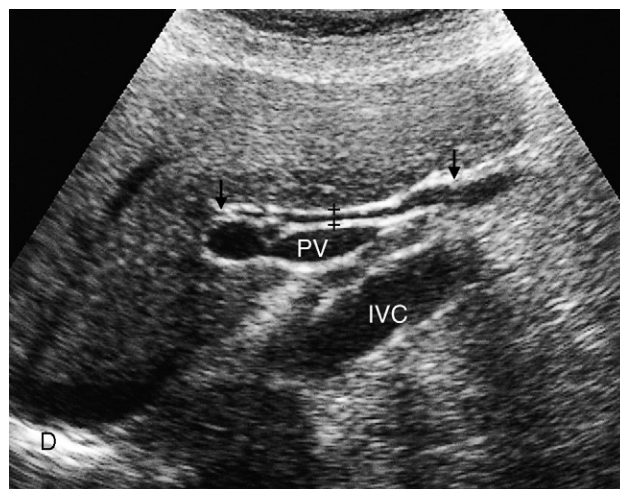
Normal common bile duct. Longitudinal ultrasound scan showing the common bile duct, situated between the arrows, lying anterior to the portal vein. The common bile duct measures 4mm in diameter (crosses). D, diaphragm; IVC, inferior vena cava; PV, portal vein.
